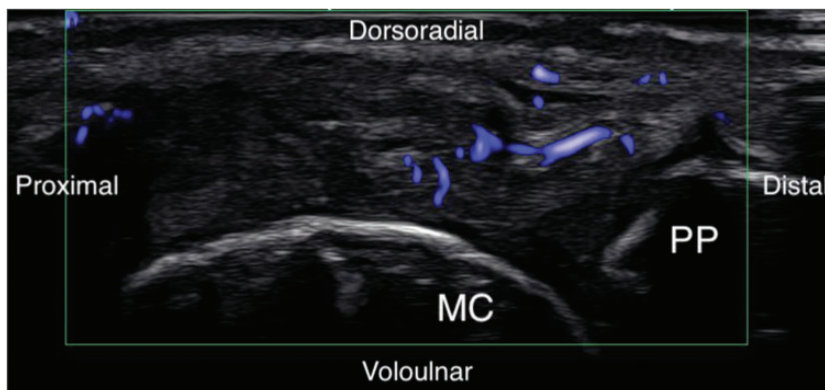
Long-axis sonogram of MCPJ of the index finger (dorsoradial aspect). Superb microvascular imaging demonstrates increased vascular flow of capsular tissue. MC: metacarpal head; PP: proximal phalanx base.
